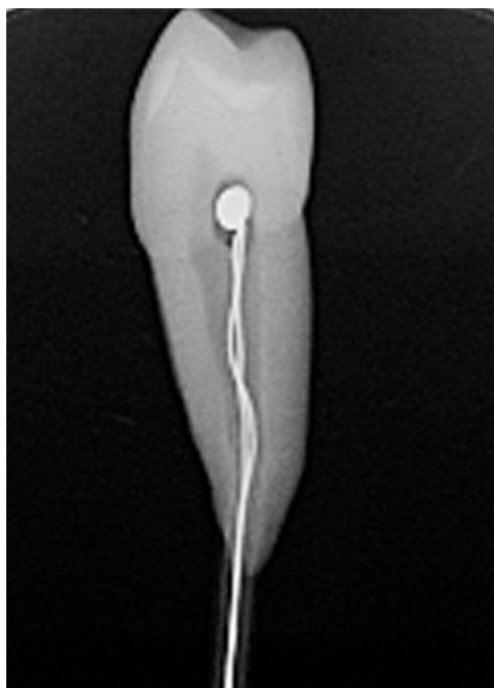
Radiographic view of the micro-thermocouple type K probe placed in the pulp chamber
